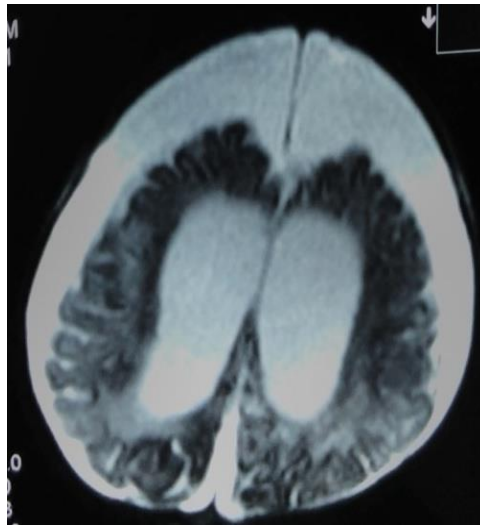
Axial T2 MRI image in a 7 months male patient shows bilateral moderate subdural effusion.
